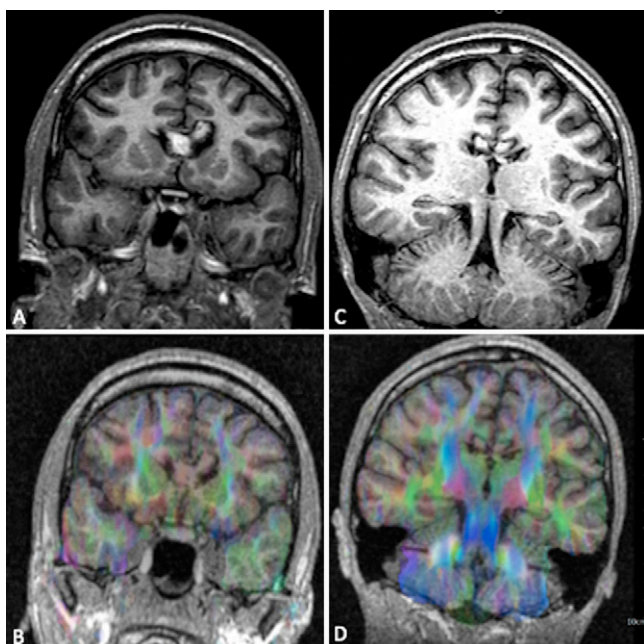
MRI sequences obtained 3 months after ablation in case 3. Coronal T1-weighted and diffusor tensor imaging MRI sequences showing overlapping areas of ablation in the genu (A and B) and body (C and D).
